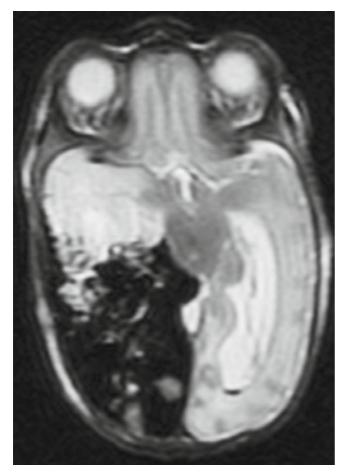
Axial T2 MRI: subarachnoid hematoma associated with gram-negative septicemia in a preterm infant
